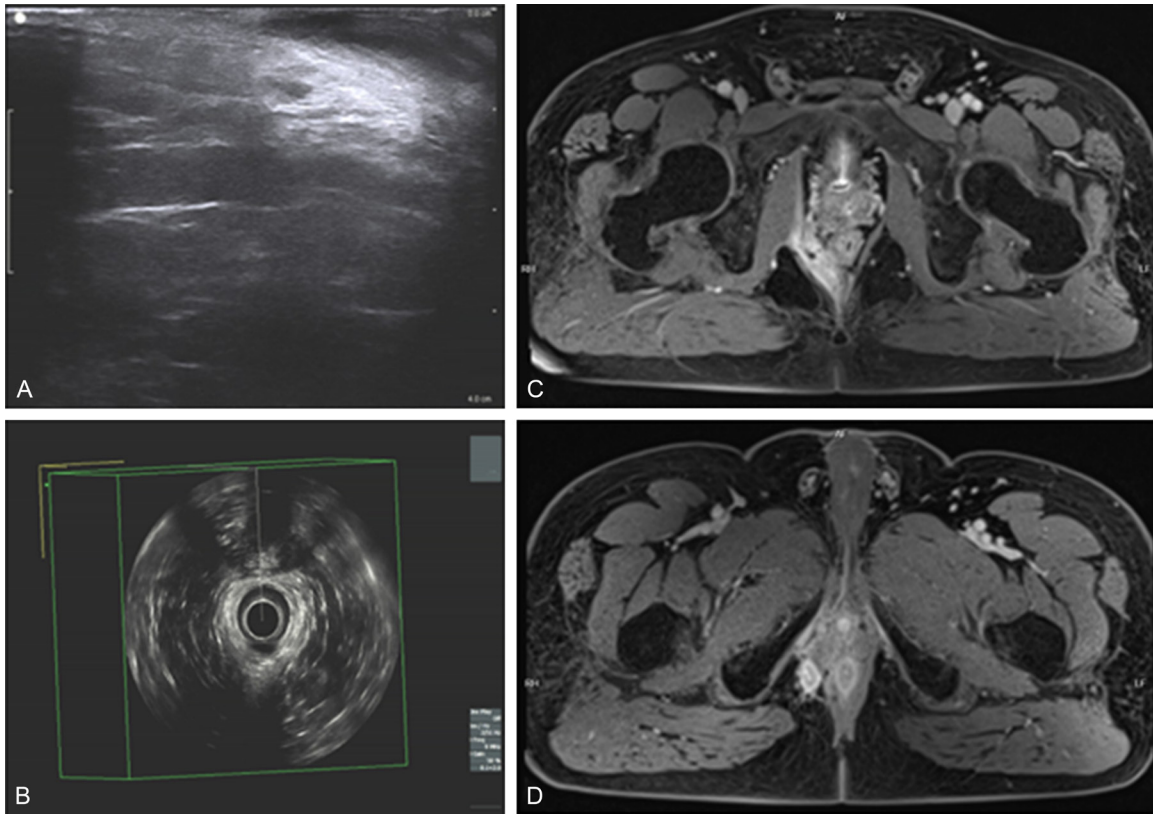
Typical ultrasound images of the two groups. A, B. Three-Dimensional Anorectal Ultrasound (3D-TRUS) images showing detailed visualization of the anal fistula, including the internal opening and fistula tract in the observation group. C, D. Magnetic Resonance Imaging (MRI) images depicting the anatomical structures and fistula tracts in the control group. The imaging modalities were compared for their diagnostic accuracy in detecting the internal opening, fistula tracts, and associated anatomical details in patients with anal fistulas.
